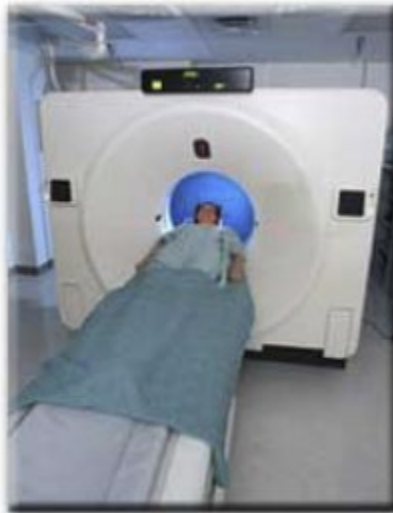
Patient being scanned in CT machine.
